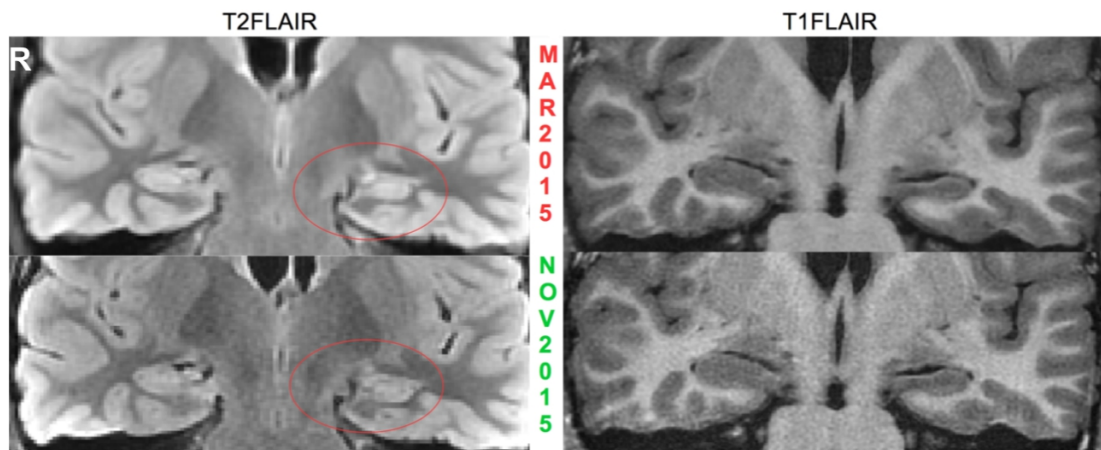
Patient 66: left HS. This patient received comparable quality of epilepsy-dedicated imaging in March and November 2015. However, HS was only diagnosed on the later images, which show hyperintensity on T1FLAIR and HA on T1FLAIR. Lesion conspicuity was similar for both MRI sessions. R = right.
